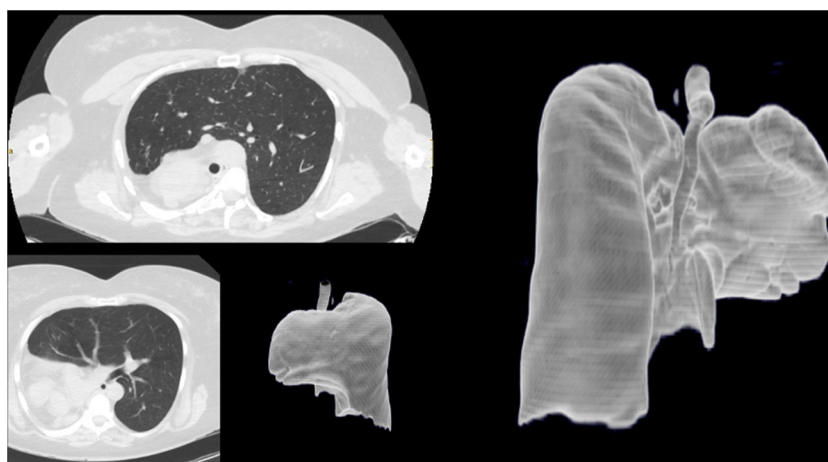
Computed tomography revealed complete agenesis of the right lung with compensatory hyperinflation of the left lung.
